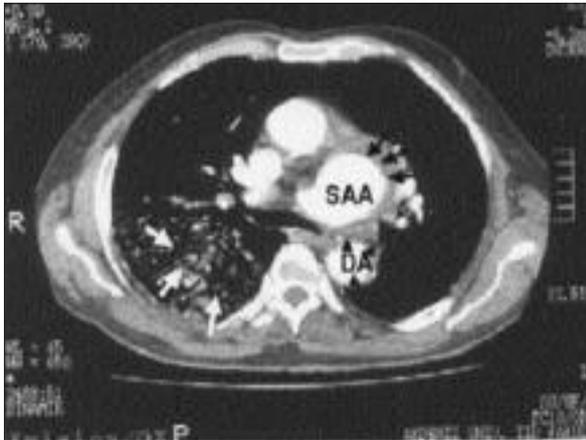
The CT scans at the level of thoracic aorta shows presence of inhomogeneous opacity in the right lung (white arrow), dilated pulmonary trunk, and thoracic saccular aneurysm containing thrombus (black arrow) in the inner surface and thrombus particles in the descending aorta (black arrowheads). But the aortopulmonary communication remains undiagnosed. The aneurysm arises just at the site of origin of the left subclavian artery.
